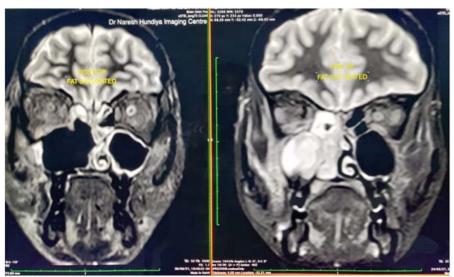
Pre-operative and Postoperative coronal MRI slice
